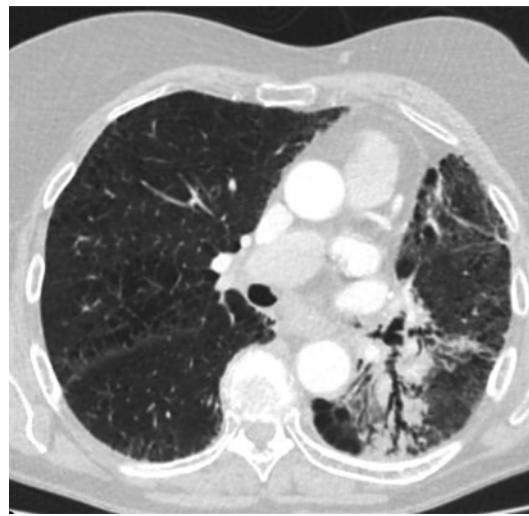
Same patient at 5 years post-radiotherapy with CT scan showing chronic post -radiotherapy fibrotic change with region of fibrosis with fairly well-defined but non-physiological borders and varicose bronchiectasis of the fibrotic region
